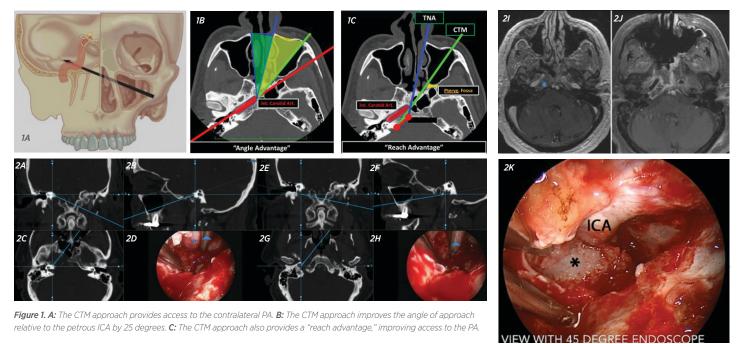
Chondrosarcoma. A-D: Intraoperative navigation showing superolateral extent of dissection to IAC. E-H: Intraoperative navigation showing inferolateral extent of dissection to parapharyngeal ICA. I: Pre-treatment MRI. J: Posttreatment MRI showing total resection of a lesion. K: Intraoperative view of horizontal petrous segment of ICA with dissection of tumor (asterisk) at entrance of carotid canal (view is rotated 90 degrees).
